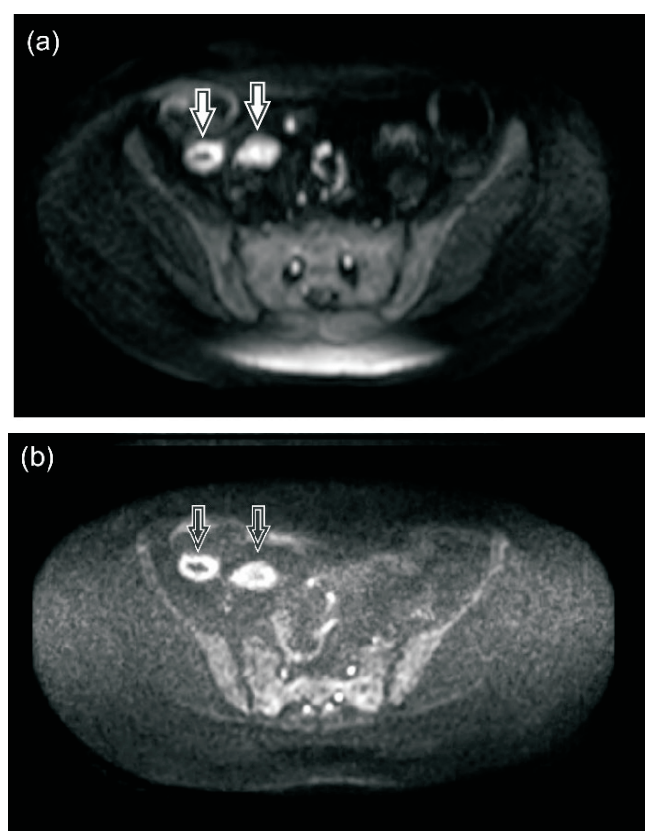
DWI (a) and DWIBS (b) images of high diffusion gradient b value = 800 mm²/s in a 56-year-old female patient with active Crohn's disease. Inflamed bowel walls present high signal intensity. The resolution of inflamed bowel and delineation of contours is better in the STIR-based DWI image (black arrows) than in the DWI image (white arrows).
